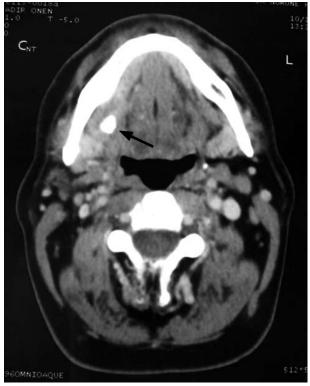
Computed tomography scan of the right submandibular gland showing the calculus (arrow) and diffuse hypertrophy.
